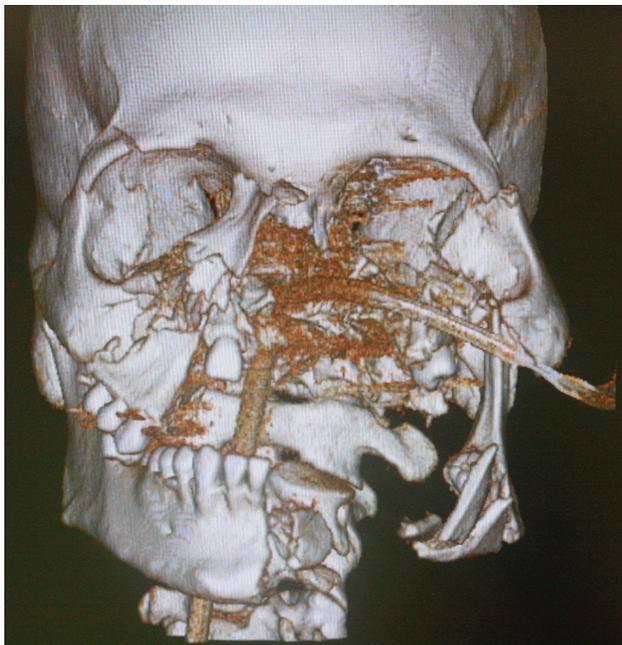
Three-dimensional CT (computed tomography) scan demonstrating the hallmark high-energy blast injury to the midface resulting in highly comminuted craniomaxillo-facial fractures of both the mandible and maxilla. Associated injuries included avulsion of the overlying facial tissues and intraoral mucosa loss.
